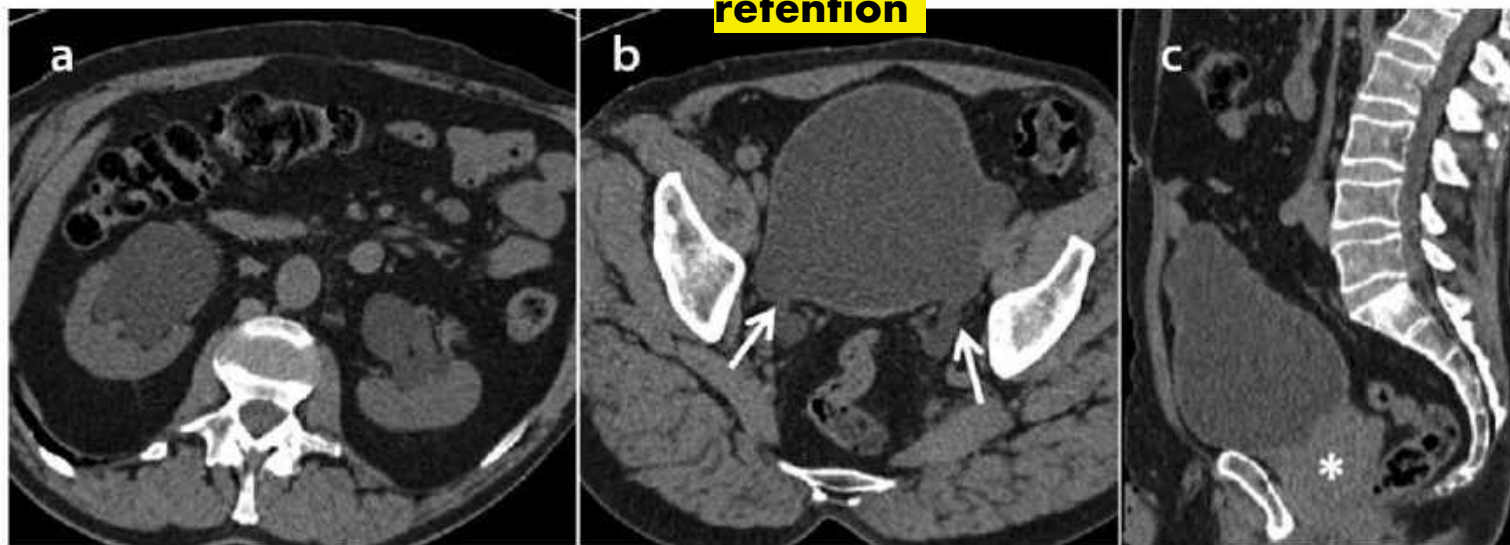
A male patient presenting with urinary retention and acute kidney injury. Axial non-contrast computed tomography (CT) images (a) of the kidneys showing bilateral hydronephrosis, and (b) of a full bladder with dilated distal ureters (white arrows) with widely patent vesicoureteric junctions; (c) sagittal CT image showing a large-volume bladder extending nearly up to the umbilicus due to a large prostate (asterisk).
